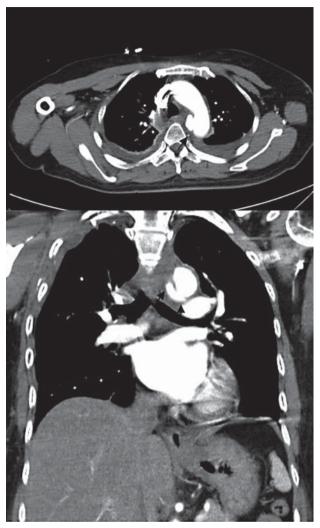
Chest computed tomography: False lumen with contrast material leaking around the isthmus of the aorta (black arrow)
